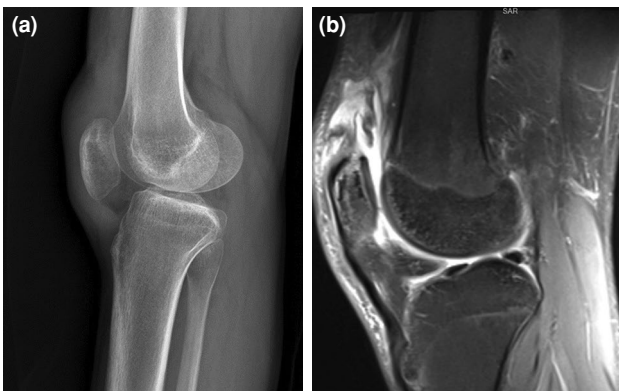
(a) Preoperative lateral knee radiograph showing the absence of osseous pathology with patella baja compatible with a quadriceps rupture. (b) Preoperative sagittal magnetic resonance imaging section showing massive retracted quadriceps rupture.
